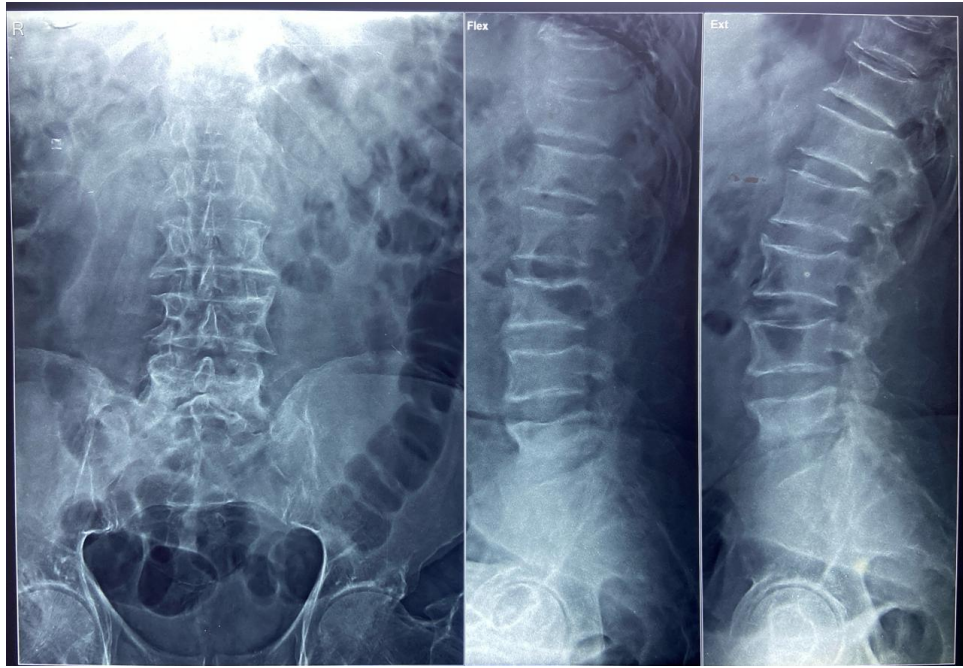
Preoperative X-ray
